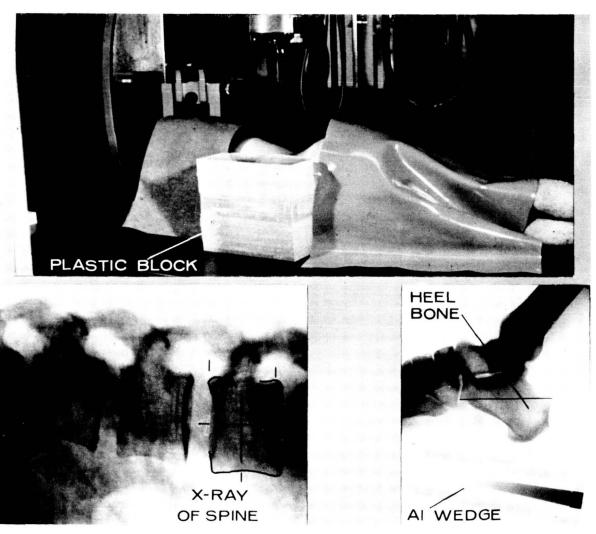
Bone X-ray densitometry studies relating to calcium loss with weightlessness. 762-318 O—65—3
